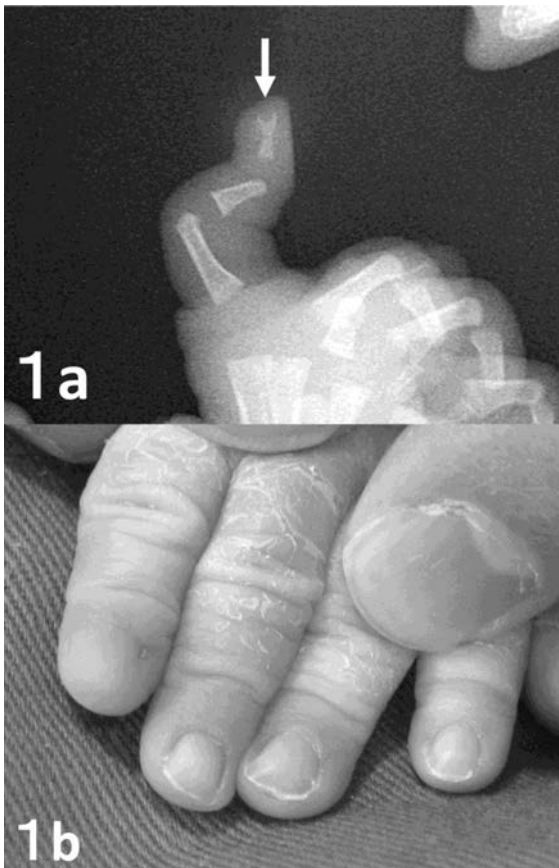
a. Radiograph shows Y-shaped bifurcation on lateral view on the left index digit, marked by an arrow. b: Micrynychia on the ulnar aspect of the left index finger.
